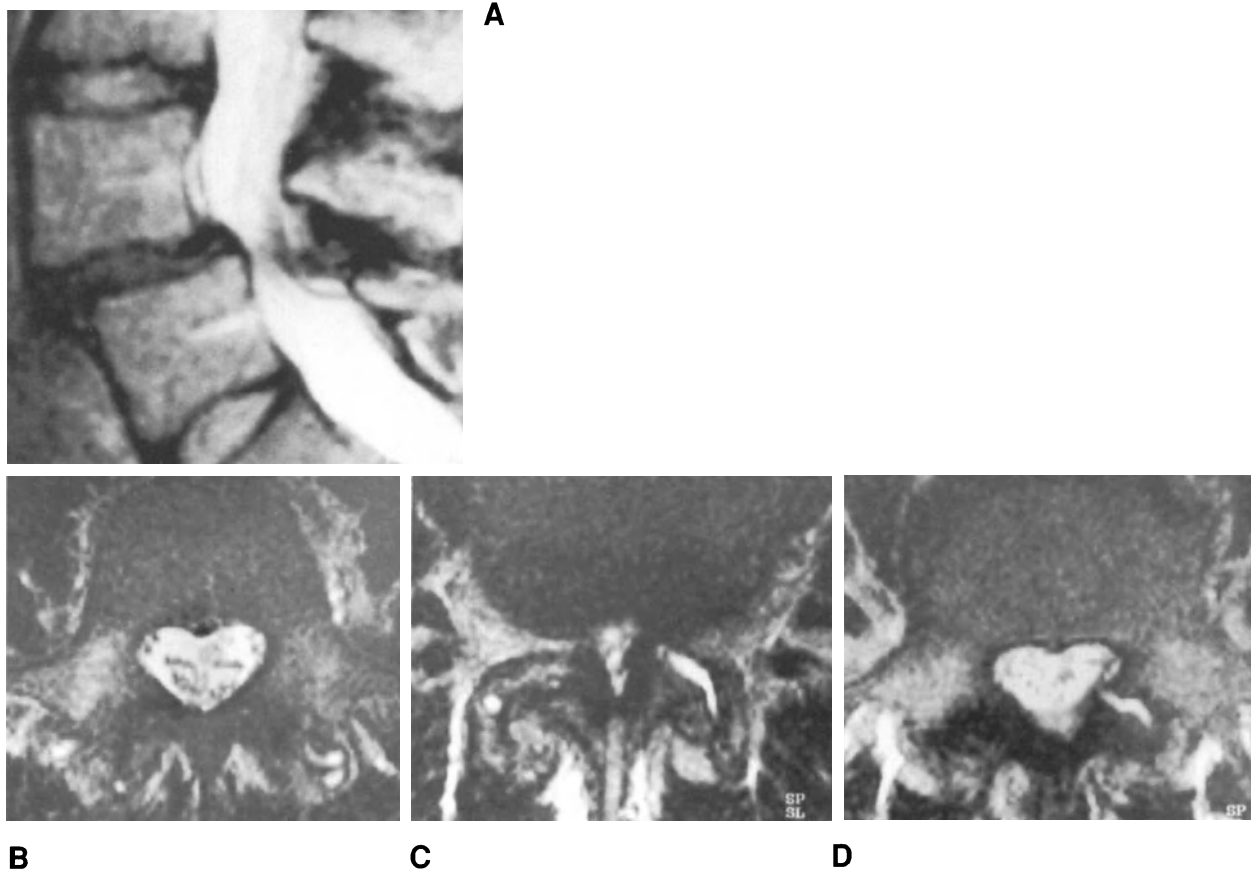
Stenosis of the spinal canal at L4-L5 level in the presence of degenerative spondylolisthesis of L4. The turbo spin-echo T2-weighted sagittal image (A) reveals marked compression of the thecal sac between the posterosuperior border of L5 and the posterior arch of L4. The spin-echo T2-weighted axial images at the level of the pedicle of L4 (B) and L5 (D) show a normal spinal canal, whereas that at L4-L5 intervertebral level (C) shows severe constriction of the canal.
